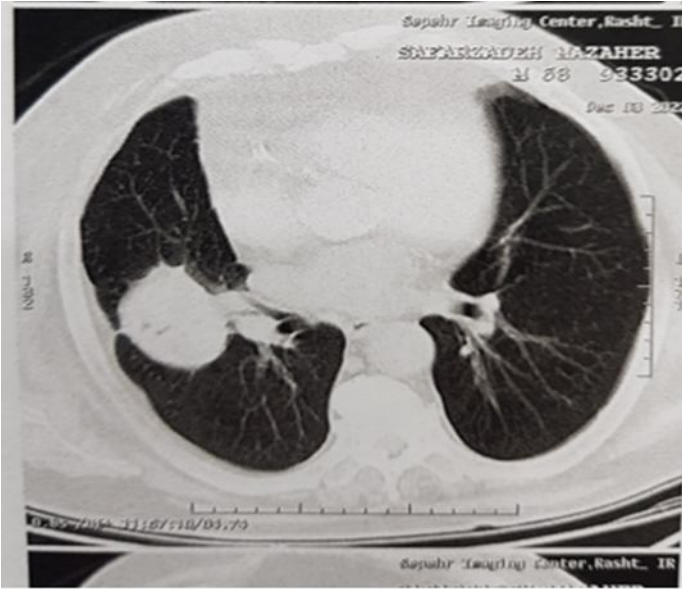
CT-scan showing mass like lesion in the RL lobe
